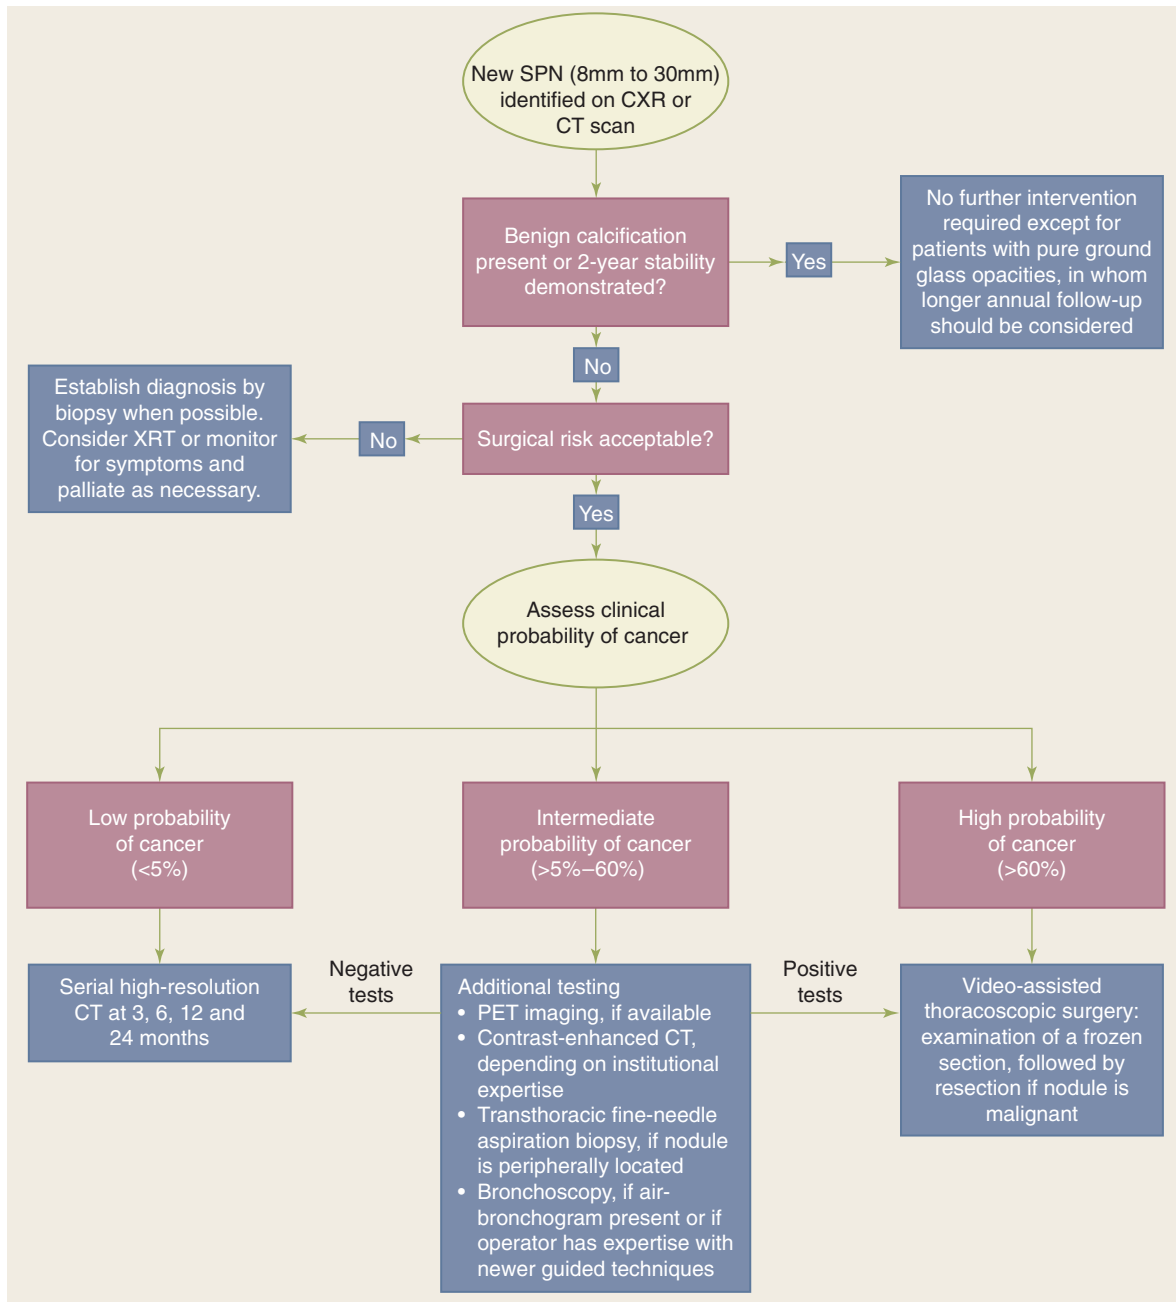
Recommended management algorithm for patients with solitary pulmonary nodules (SPNs) measuring 8 mm to 30 mm in diameter. CT = computed tomography; CXR = chest radiograph; PET = positron emission tomography; XRT = radiotherapy. (Reproduced with permission from the American College of Chest Physicians from Gould MK, et al. *Evaluation of patients with pulmonary nodules: when is it lung cancer?*: ACCP Evidence-based Clinical Practice Guidelines. (2nd edition) Chest. 2007;132:108S.)
